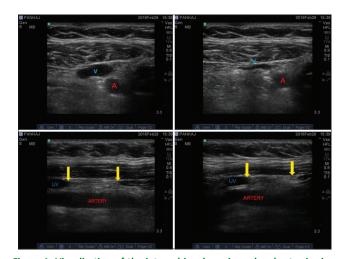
Visualization of the internal jugular vein under short-axis view of ultrasound and long-axis view of the lower part of the internal jugular vein shows noncompressible, hyperechoic thrombus along with fibrosis
